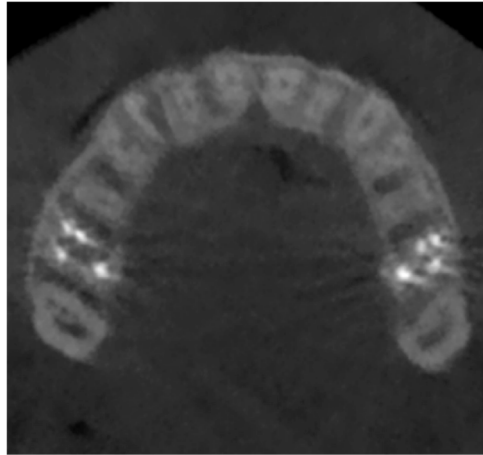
CT, one month after the Le Fort I, which shows a fracture line close to element 13.
